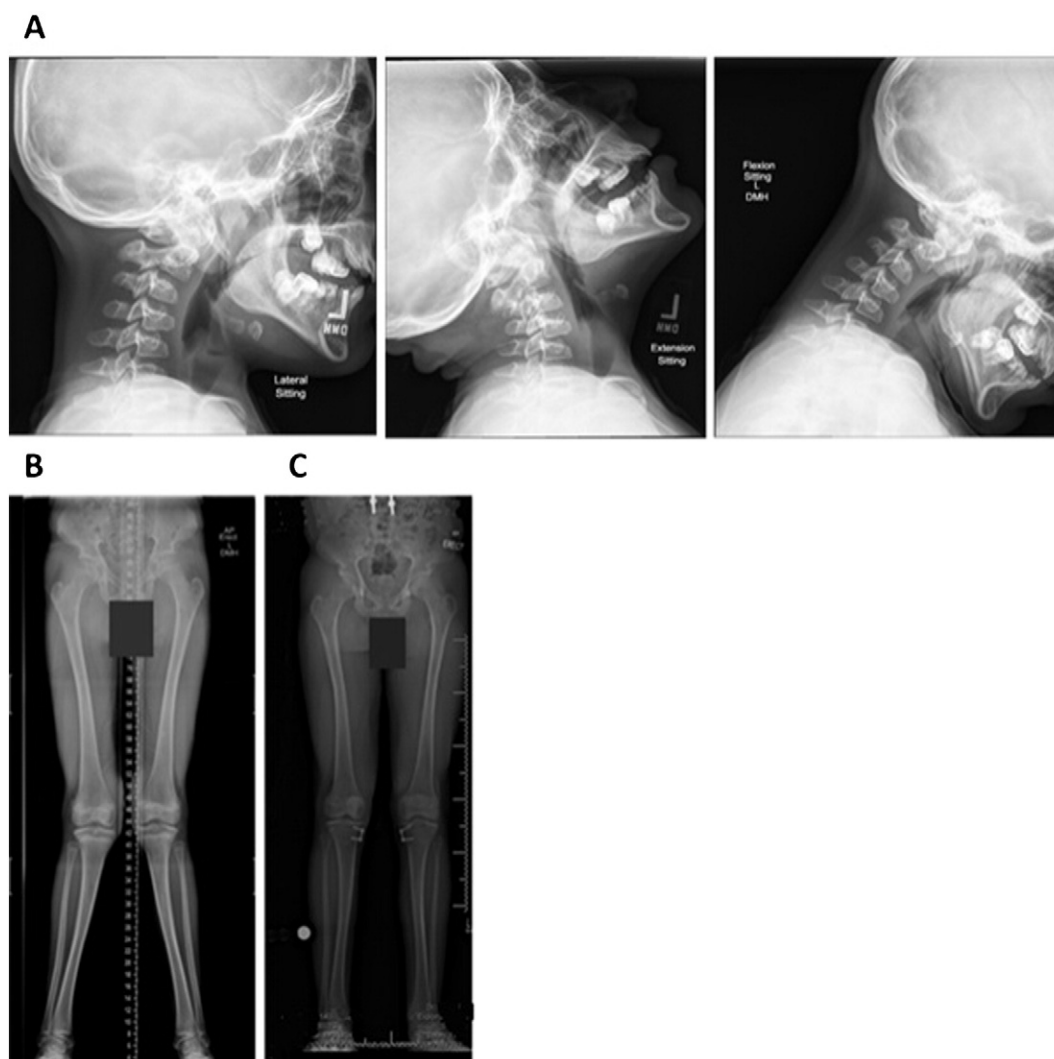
X-rays at 12.4 years of age. A) Cervical spine: Dysmorphic changes of the cervical vertebra with widening of disc spaces and narrowing of the spinal canal consistent with underlying MPS I. No evidence of cervical spine instability is seen. B) Lower extremities: Pre-operation – The bony mineralization is within normal limits. Redemonstrated is the bilateral genu valgum, right greater than left. Both femoral heads are well covered by their respective acetabula and better covered than they had been on the prior examination. There is no acute fracture, dislocation or joint abnormality. C) Post-operation – Postoperative changes for epiphysiodesis in the medial aspect of the bilateral proximal tibia remain in place. Bilateral hips are well located. Bilateral genu valgus is still noted. No focal abnormality is seen. Joint spaces are maintained. Soft tissues are unremarkable. Stable mild bilateral genu valgus with generalized osteopenic is observed.
